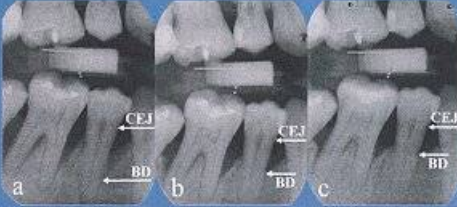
a, b, c: standardized radiographs of an infrabony defect mesial 45 at baseline (a), 12 (b), and 60 months (c) after GTR-therapy with a polydisoxanone barrier. CEJ (cemento-enamel-junction), BD (most apical extension of bony defect).
